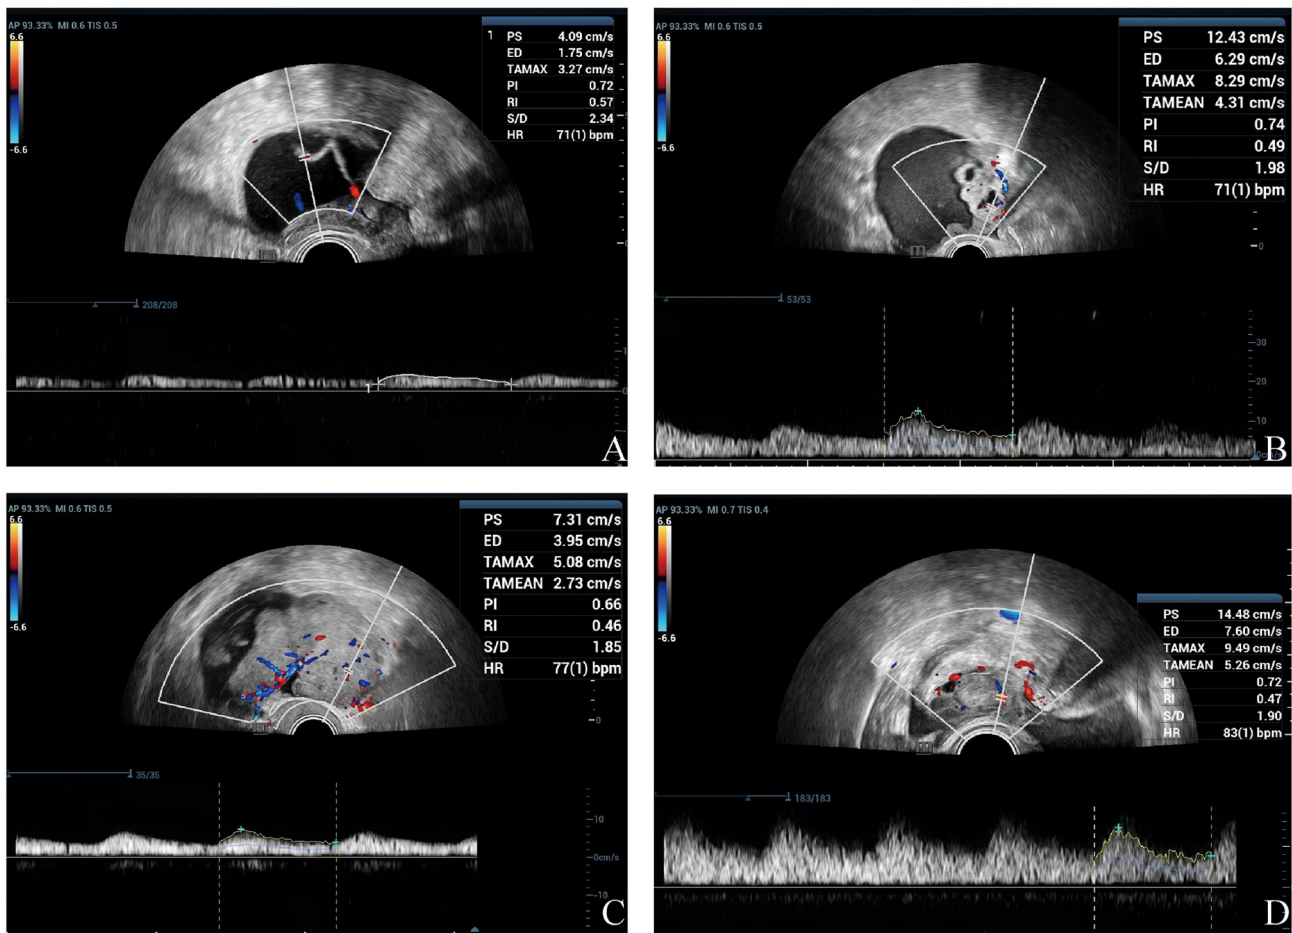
Image features of ultrasonic O-RADS classification. (A) The tumor had a regular contour and was a cystic mass with septa visible inside. A few punctate blood flow signals could be detected within the septa. It was classified as O-RADS category 3 and the pathological diagnosis was serous cystadenoma. (B) The tumor was relatively regular in shape with multiple septa and irregular solid masses visible inside. A few blood flow signals could be detected around it. It was classified as O-RADS category 4 and the pathological diagnosis was high-grade serous cystadenocarcinoma. (C) The tumor had a relatively regular contour was a cystic-solid mass. The cystic part had favorable sound transmission while the solid part had an unclear shape and boundary with irregular in shape and abundant blood flow signals could be detected. It was classified as O-RADS category 4 and the pathological diagnosis was borderline serous papillary cystadenoma. (D) The tumor had a regular contour and was mainly composed of solid components and punctate blood flow signals could be observed around it. It was classified as O-RADS category 4 and the pathological diagnosis was corpus luteum. O-RADS, ovarian-adnexal reporting and data system.
